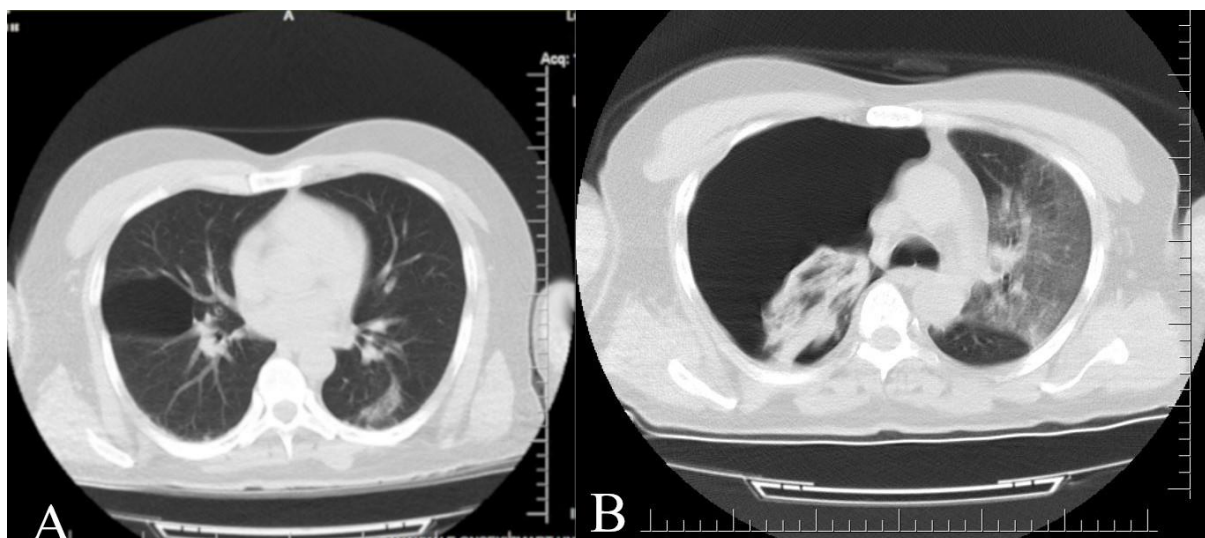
A) CT image revealing bulla on the right middle lobe. B) CT image revealing the right-sided pneumothorax.
